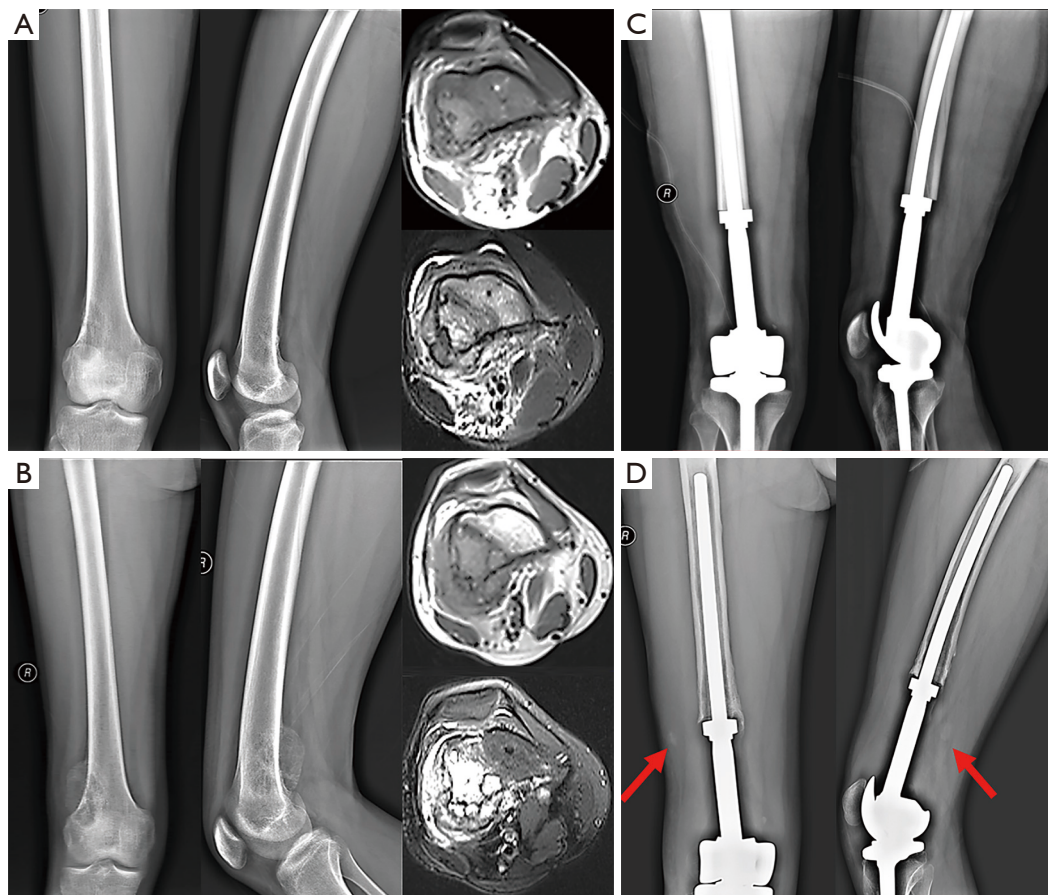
Images of the patient. (A) X-rays and MRI before NAC. (B) X-rays and MRI after 3 times chemotherapy. (C) Postoperative X-rays. (D) X-rays of the first local recurrence at 10 months after surgery. Red arrows indicated the lesion of relapse.
